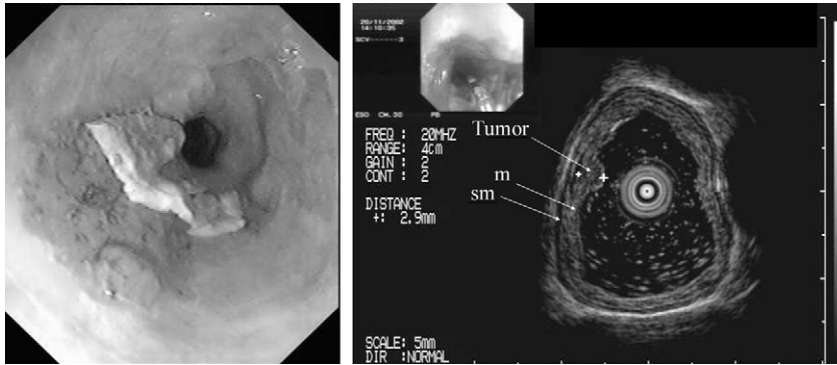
Early mucosal adenocarcinoma in Barrett's esophagus. Endoscopic view (left) shows small slightly elevated lesion of the lower third of the esophagus (type 0-IIa). Endoscopic ultrasonography with 20-MHz mini-probe (right) shows the small, slightly elevated lesion, homogeneous on echo, with circumscribed thickening of the mucosa. Pathologic examination revealed a T1m lesion (mucosectomy). (m = mucosa; sm = submucosa.)
